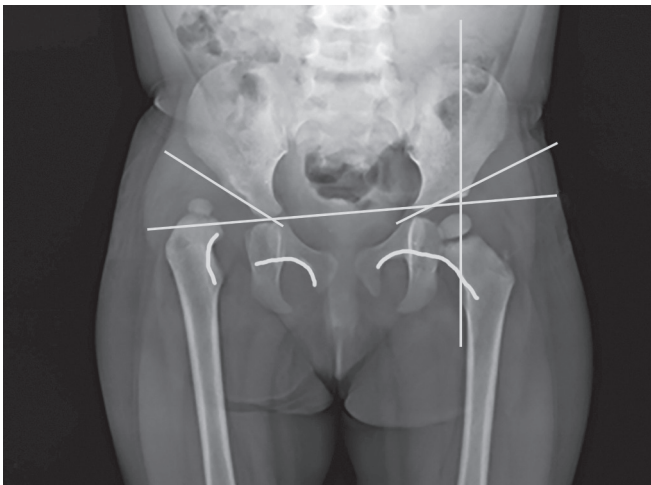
Anteroposterior radiograph of a 2-year old child with DDH of right hip. The right hip shows break in the Shenton's line and increased acetabular index (40°)
